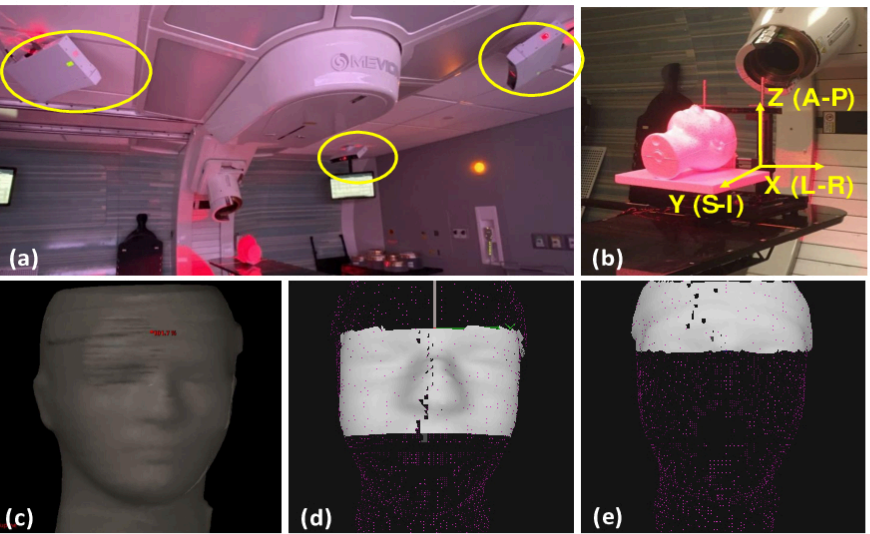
(a) The setup of Optical Surface Monitoring System (OSMS), which consists of three ceiling camera pods; (b) each camera projects a red light speckle on the patients; (c) a reference surface is generated by imposing the body contour from planning CT dataset; and (d) a region of interest (ROI) is selected and rigidly aligned with the reference surface, with central face selected as the ROI, or (e) forehead can be selected as the ROI.
